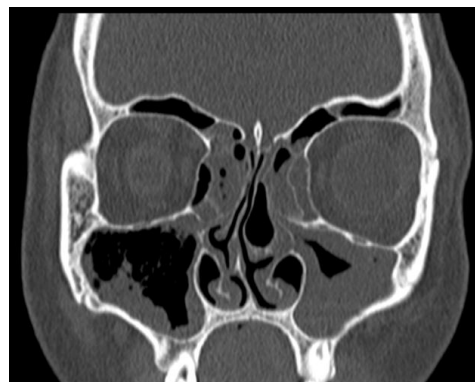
Coronal reconstructed CT scan showing left sided concha bullosa with nasal septal deviation to right and bilateral maxillary and ethmoid sinusitis.
